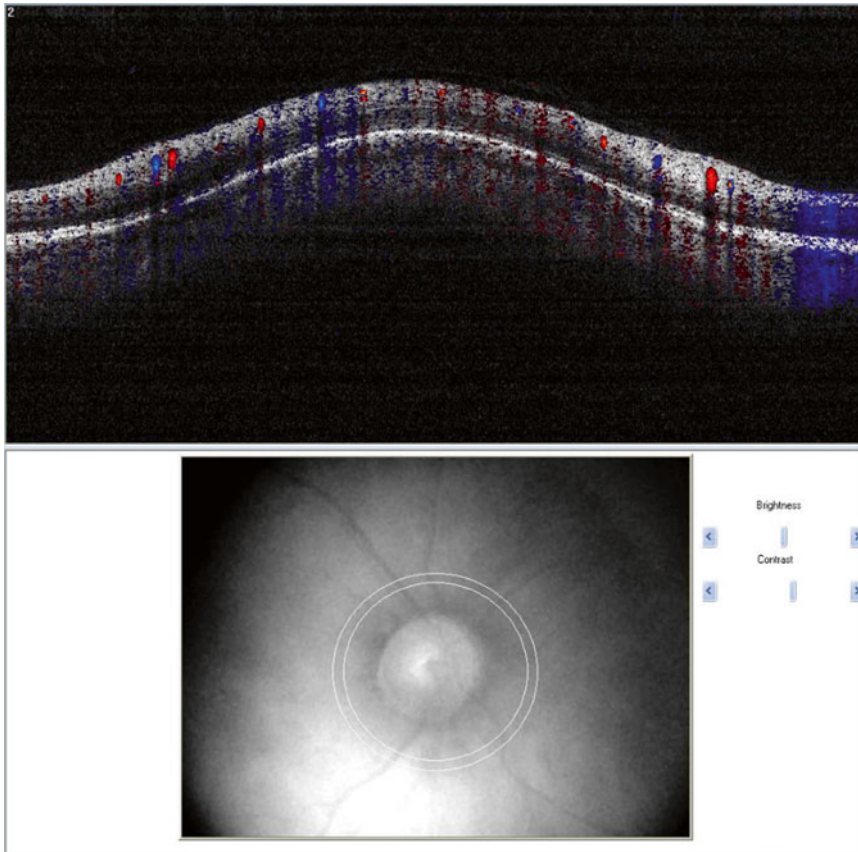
FD-OCT image showing the unfolded cross-section from a circular scan. Arteries and veins could be distinguished by the direction of flow as determined by the signs (*blue or red* color) of the Doppler shift and the angle θ
